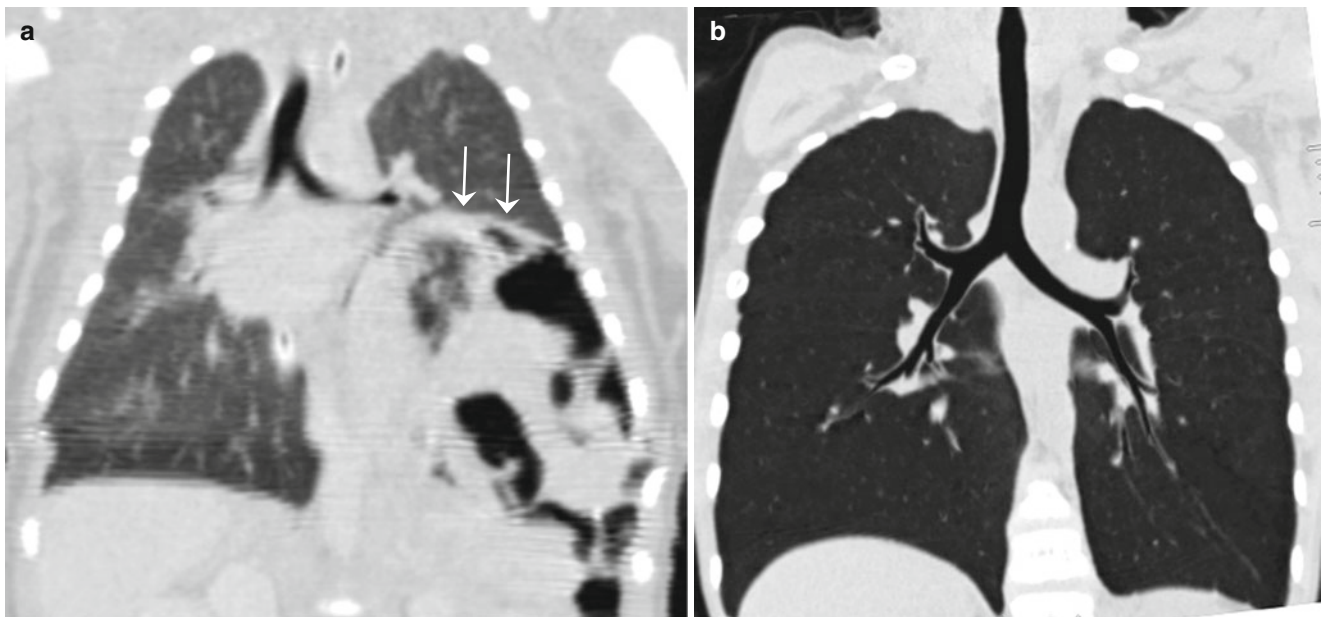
(a, b) Congenital left diaphragmatic hernia. Coronal CT image shows the herniated abdominal contents (*arrows*) displacing the left lung upward (a). Coronal CT image 6 years after the diaphragmatic
